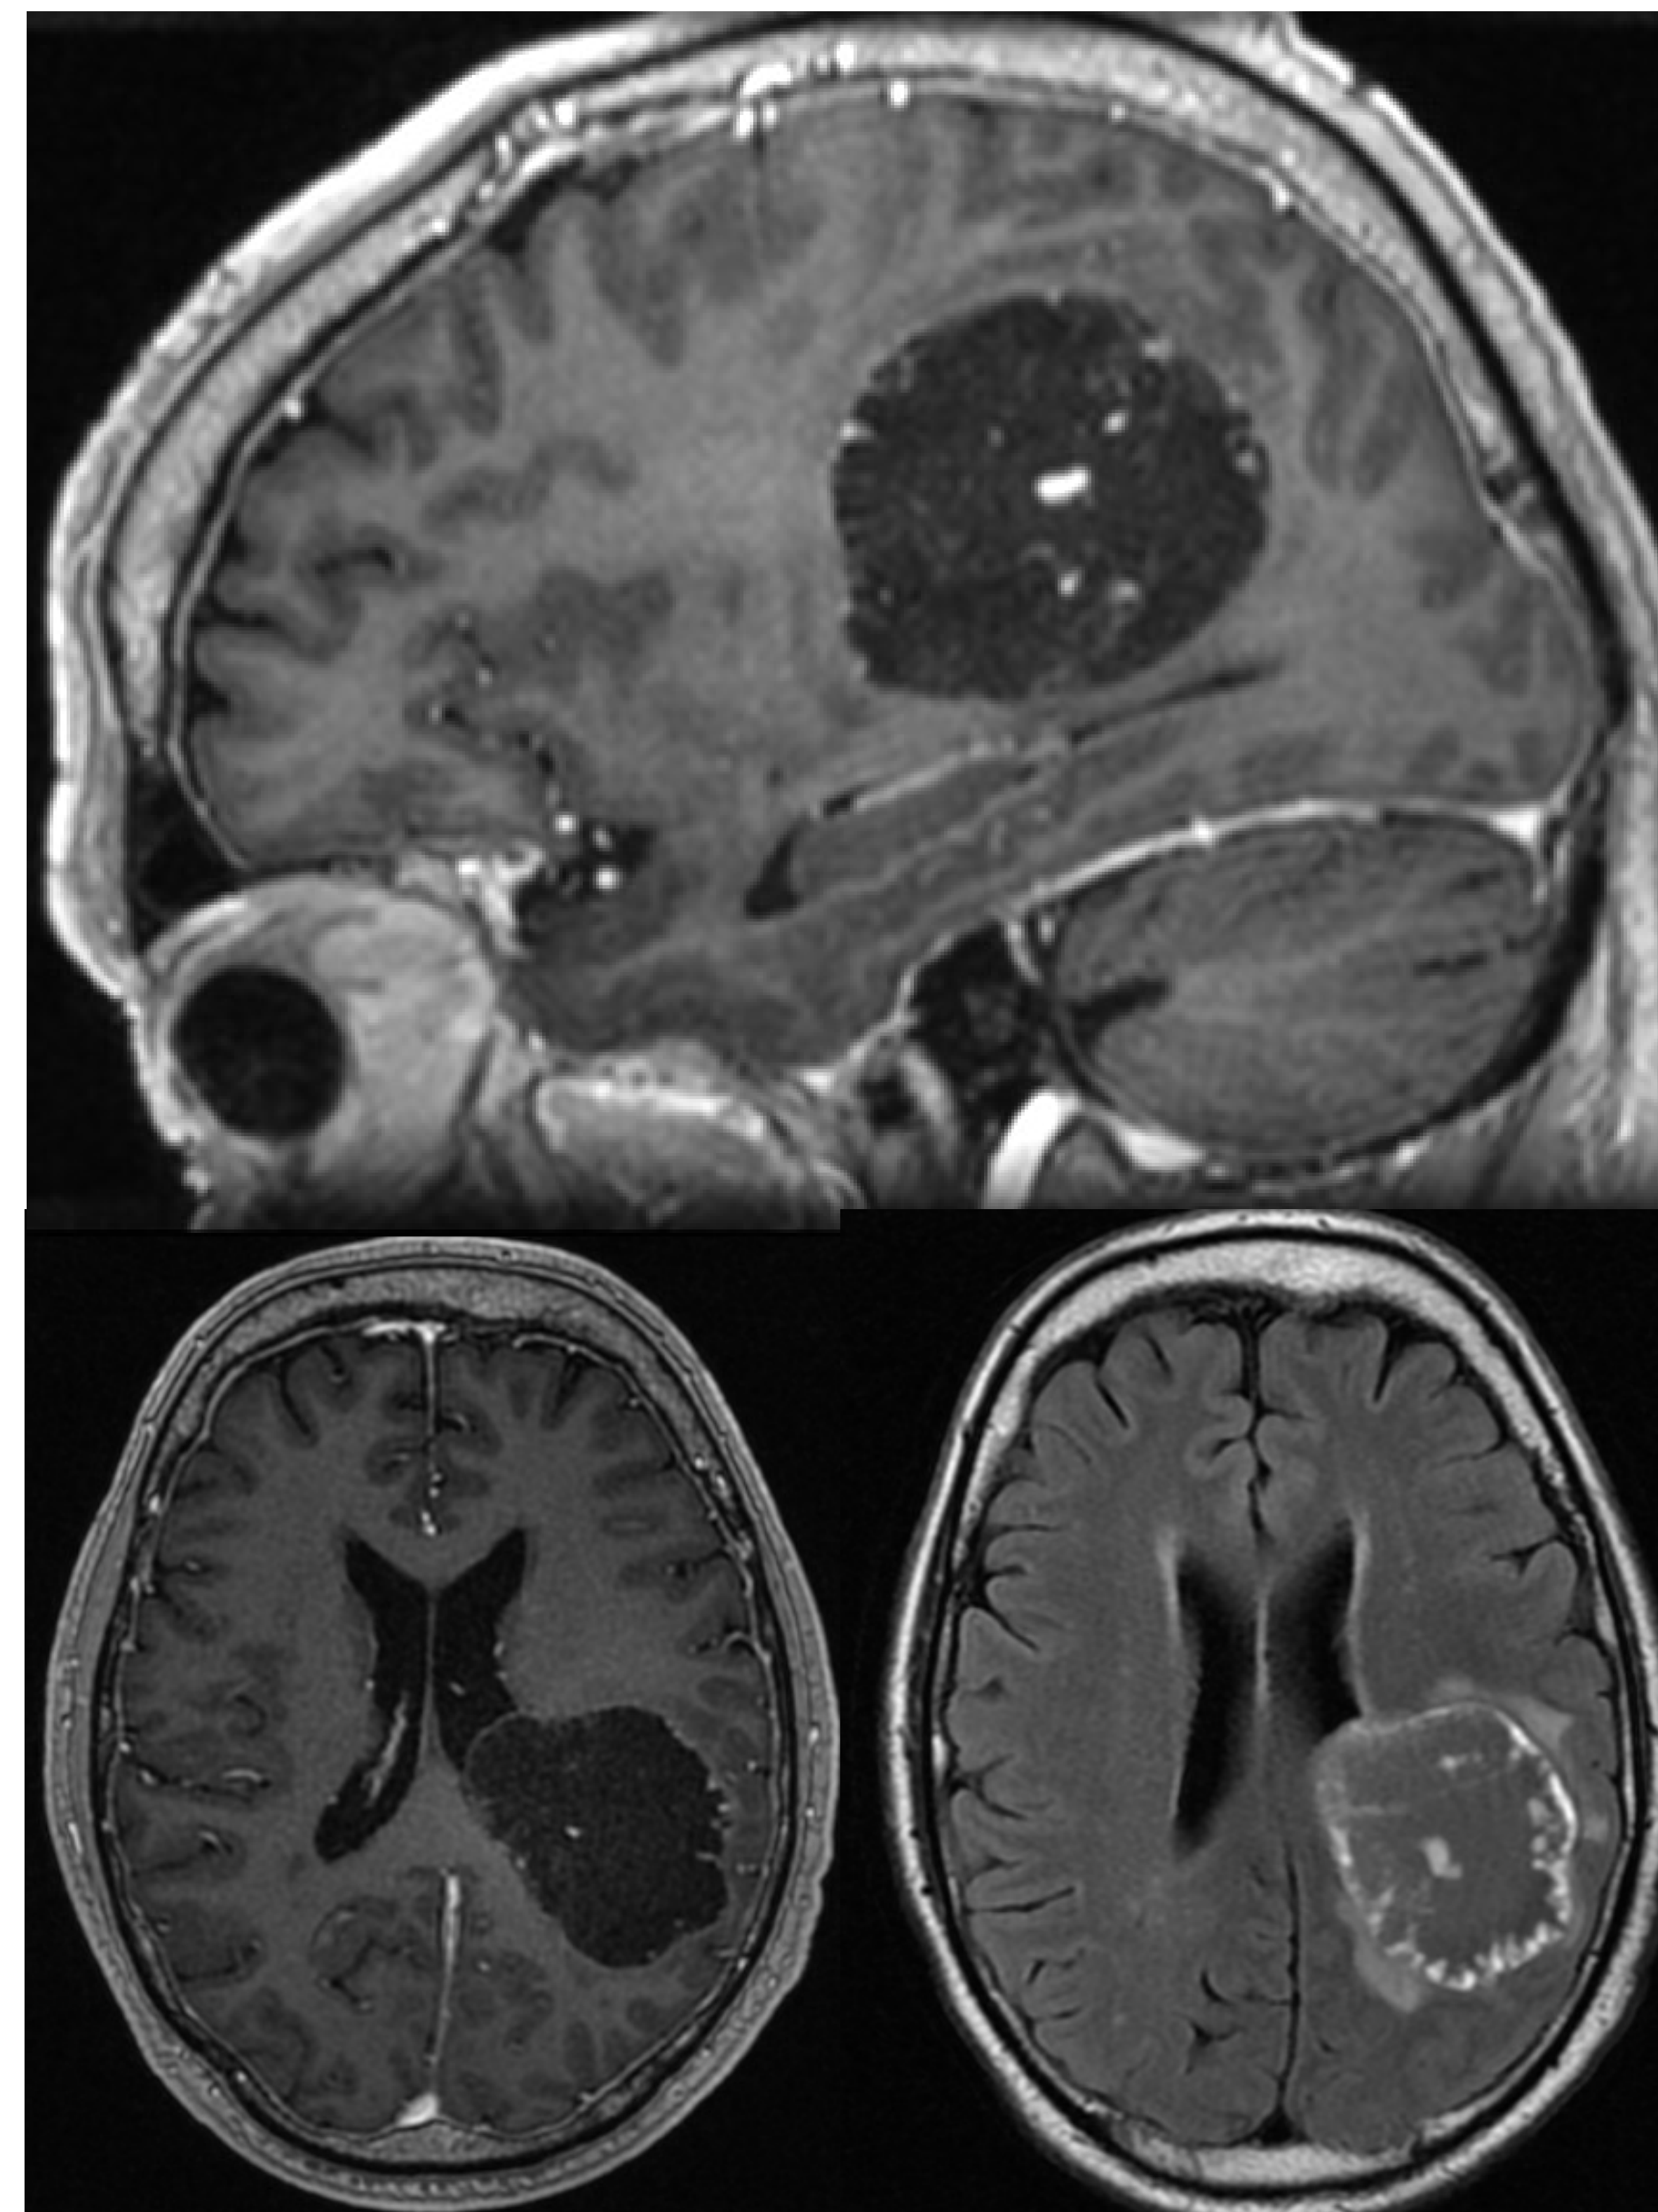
MRI of large left posterior cerebral parenchymal lesion approximately 5.4 x 4.8 x 4.4 cm with mass effect and surrounding vasogenic edema and sulcal effacement of left parietal lobe
